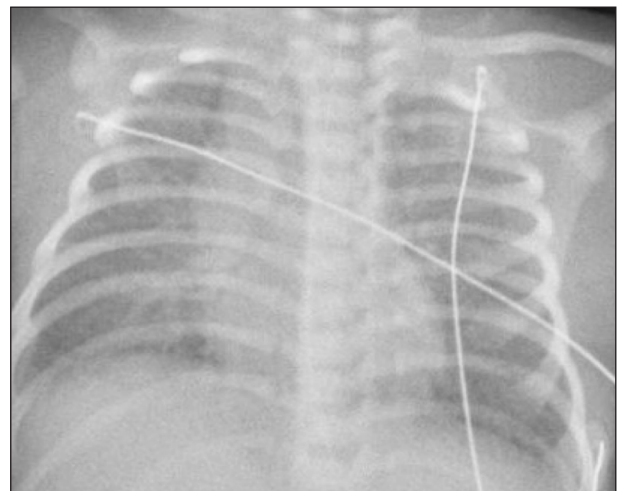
Chest radiograph showing pulmonary congestion without any other abnormalities.
